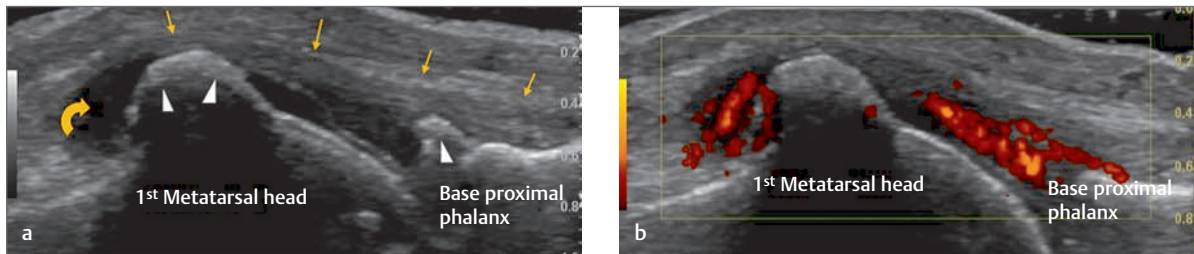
(a) Longitudinal image of the first metatarsophalangeal joint of the great toe. The image demonstrates marked degenerative change with bony exostosis at both the head of the metatarsal and at the base of the proximal phalanx (white arrowheads). Effusion is noted in the joint and also the metatarsal recess (curved arrow). The joint capsule is thickened (yellow arrows). (b) With Power Doppler the joint may also be seen to exhibit a marked synovitis. These findings are in keeping with a marked osteoarthritis and associated synovitis of the first metatarsophalangeal joint of the great toe. White arrowheads, bony exostosis; yellow arrows, hypertrophy of the joint capsule.
